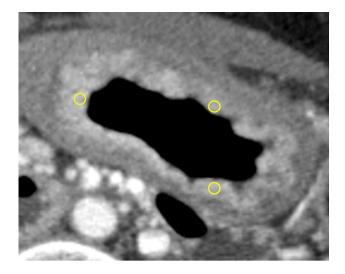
Measurement of CT attenuation values. This case shows circumferential gastric wall thickening with a double-layered pattern in the arterial phase on an axial image. Three circular ROIs were drawn in the inner layer to measure attenuation values
